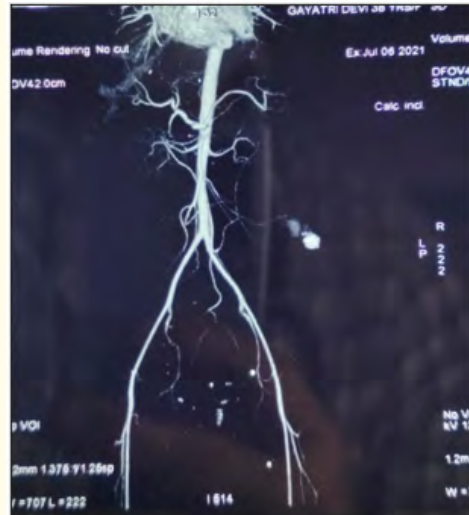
CT angiography showing the central nidus of the lesion dilated, with tortuous vessels.
